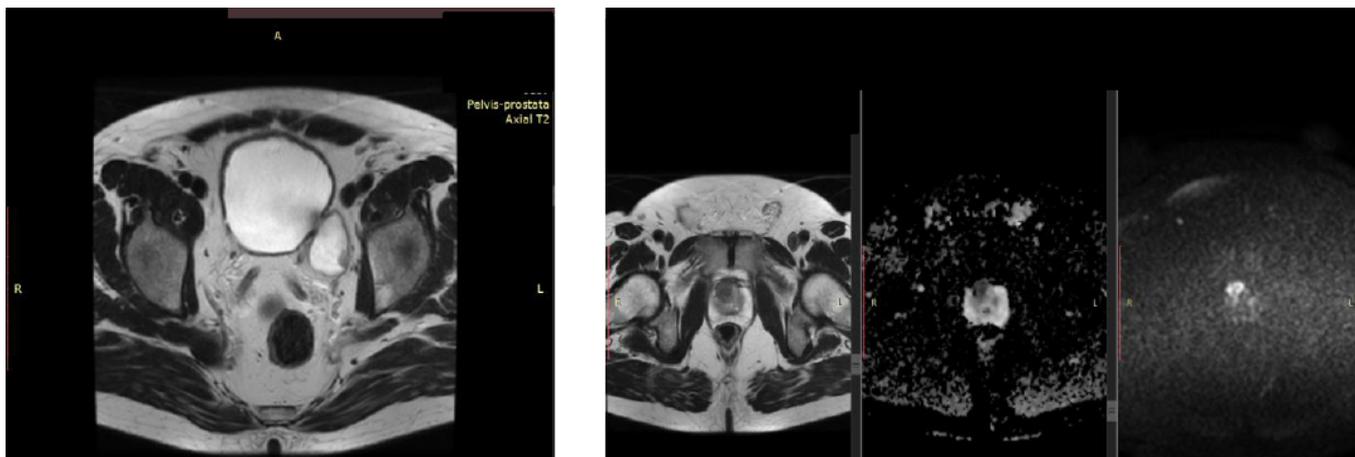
Magnetic resonance imaging scan shows on the left a bladder diverticulum on the left lateral-posterior wall with a tumor (11/7 mm). On the right, magnetic resonance imaging scan demonstrates a 22 mm, T2-hypointense lesion, hyperintense on DWI, localized in the anterior transitional zone (TZa) and anterior fibromuscular stroma (AFMS) of the right prostatic lobe, classified PI-RADS 5.
